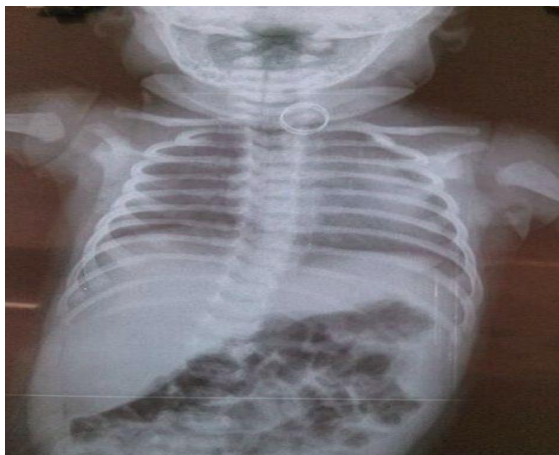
X-ray Soft tissue neck Anteroposterior view
